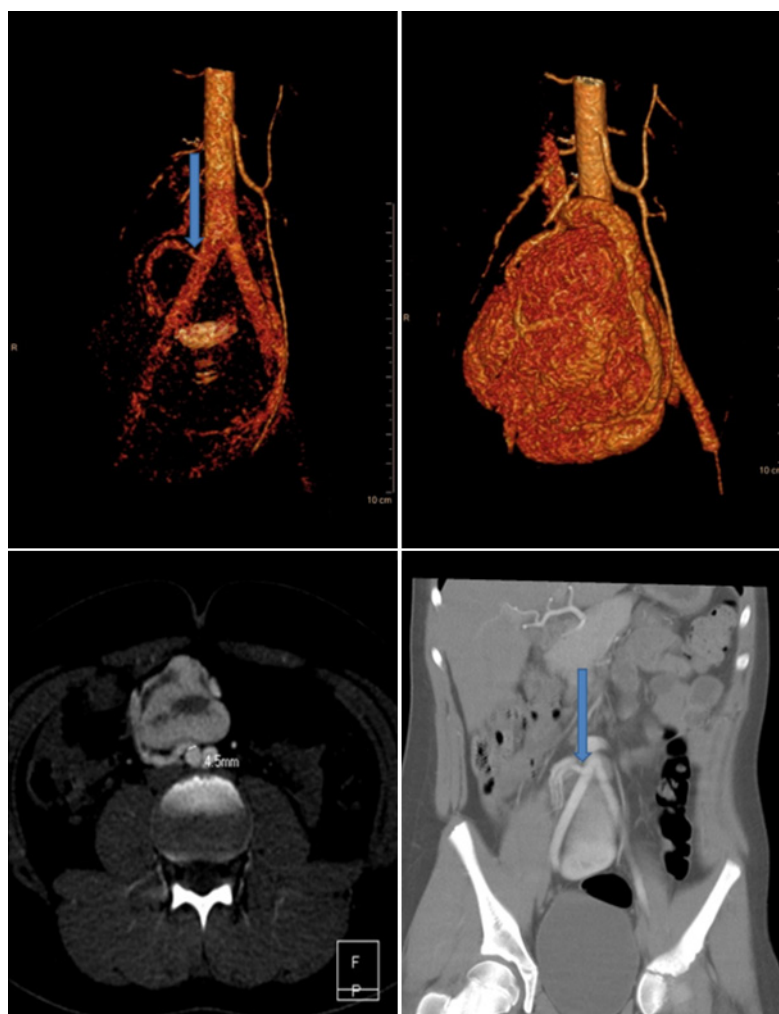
A computed tomography (CT) angiography: right renal artery arising from the right common iliac artery with the bending and compression between the urinary bladder, right kidney, and right common iliac artery (blue arrow — bending of the right renal artery)
